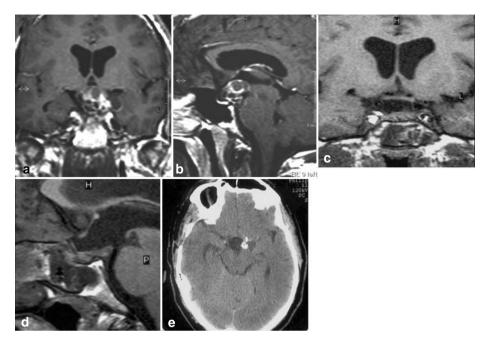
a, b) Coronal and sagittal pre-operative MRI images showing a case of suprasellar craniopharyngioma already operated through a right pterional approach. c, d) Coronal and sagittal post-operative MRI images of the same patient showing the subtotal removal of the lesion. e) Early post-operative CT scan. Note the calcified remnant of the tumor
